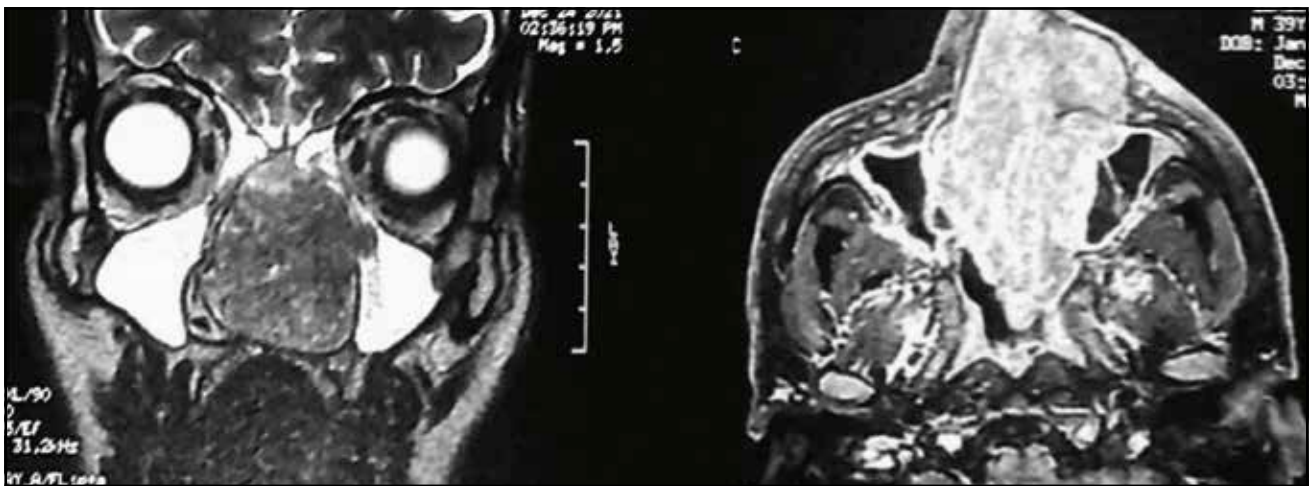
Cranio-facial MRI, coronal section T2 sequence and axial section T1 FAT SAT sequence, objectified an iso-signal tumor lesion of the left nasal fossa, locally advanced, but without endocranial or endo-orbital extension.
